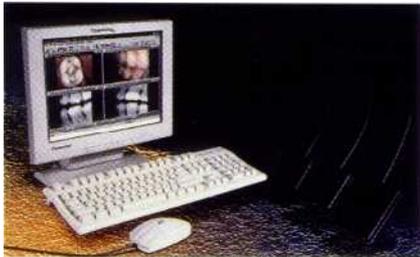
A corded digital radiographic system. (Courtesy Schick Technology, Inc.)
